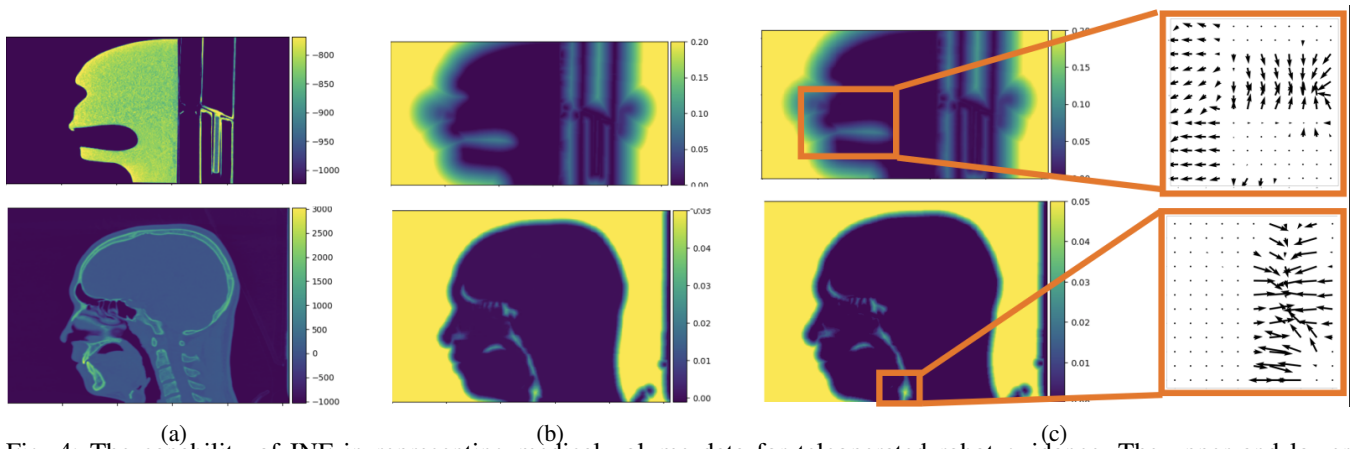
The capability of INF in representing medical volume data for teleoperated robot guidance. The upper and lower rows show the results from a scanned silicone head model and a real human head. (a) The original slice of the CT scan. (b) The distance field prepared by distance transform. (c) The distance field reconstructed by INF and the gradient of the distance field produced by INF in the cavity region.
